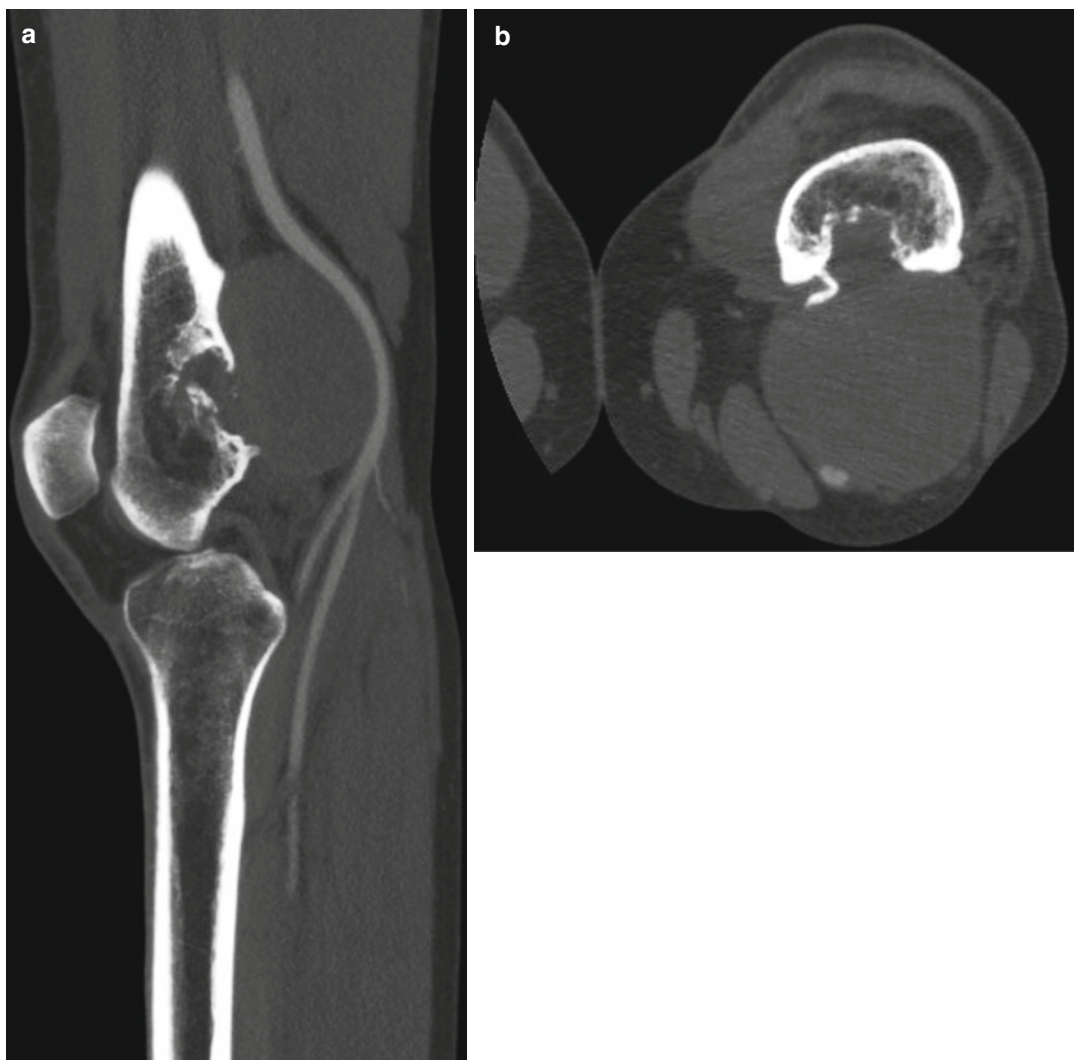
CT of a hemophilic pseudotumor and its relationship with the popliteal artery: (a) sagittal view; (b) axial view
